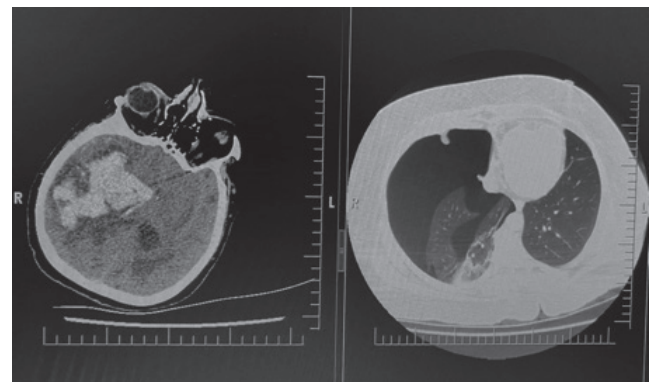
Thorax CT revealed pneumothorax in the right lung.
